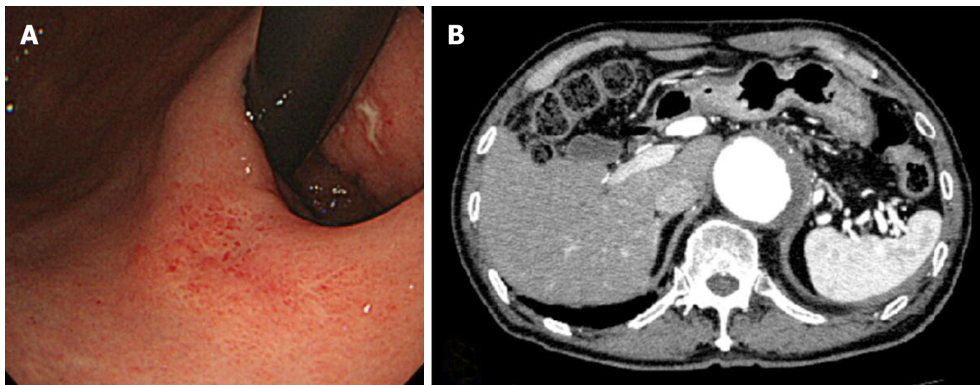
Objective image findings after chemotherapy. A: EGD finding after chemotherapy. The lesion became unclear. It appeared smooth and protruded, and looked like a submucosal tumor; B: Abdominal CT with contrast after chemotherapy showed multiple lesions had disappeared and no evidence of disease in the liver. EGD: Esophagogastroduodenoscopy; CT: Computed tomography.
